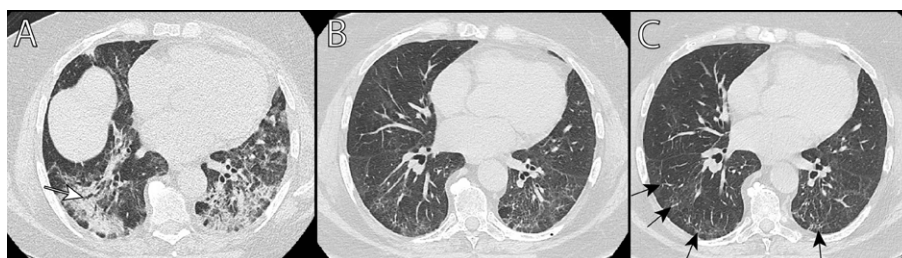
(A) CT at initial COVID-19 presentation. Bilateral multifocal organizing consolidations with bronchiectasis (white arrow) and surrounding ground glass opacities. (B) 3 month follow-up CT. (C) CT obtained after 6 months. Almost complete resorption of ground glass opacities with persisting subpleural curvilinear parenchymal bands (black arrows)
